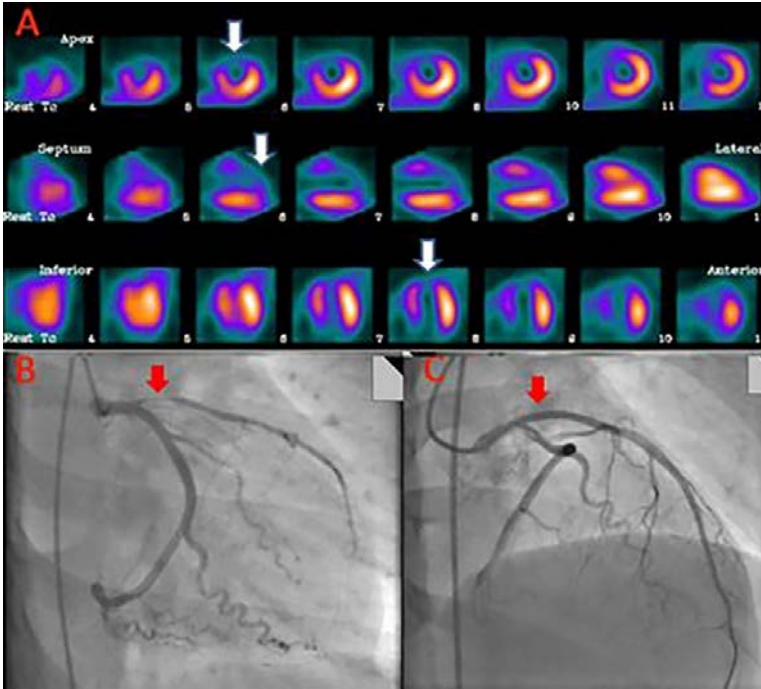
Rest SPECT MPI and invasive coronary angiography. (A) The SPECT images depict short axis images (top row), vertical long axis images (middle row) and horizontal long axis images (bottom row). These images show a large sized and severe perfusion defect throughout the anterior and anteroseptal walls and the apex. (B) Invasive coronary angiography shows a tight stenosis in the proximal left anterior descending artery (indicated by arrow). (C) The stenosis was successfully stented (indicated by arrow).
